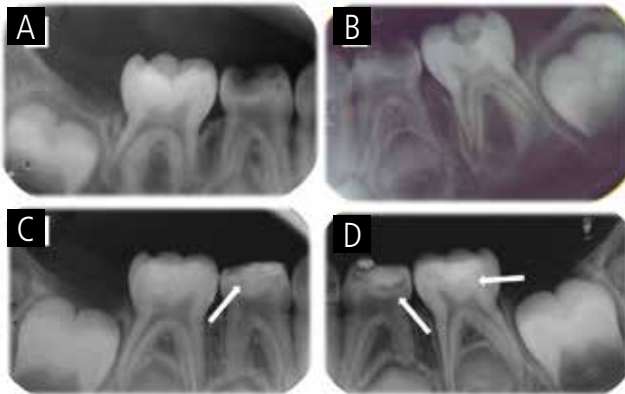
Radiographs of deciduous molars before (A-B) and 16 months after ART restorations (C-D). The presence of a more mineralized dentin tissue can be seen under the restorations; no signs of pathological pulp conditions are present. The development of permanent teeth is occurring as expected.
